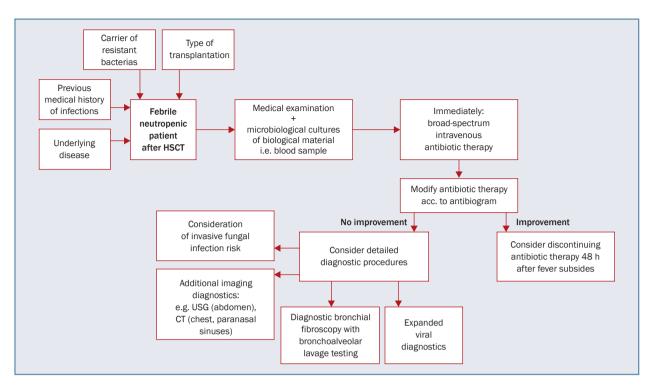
Practical algorithm of febrile neutropenic patient after hematopoietic stem cell transplantation (HSCT); USG – ultrasonography; CT – computed tomography
